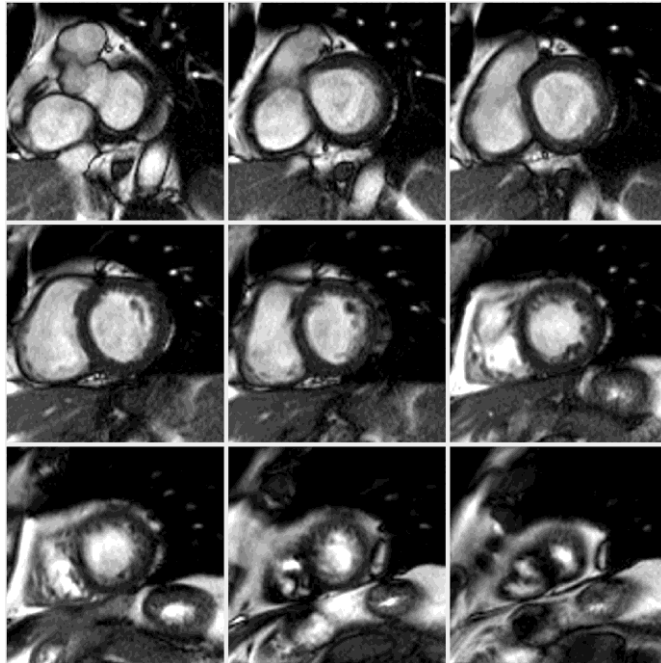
Multi-slice cardiac MRI stack in short-axis view at end-diastole. The top-left image represents the most basal slice.
